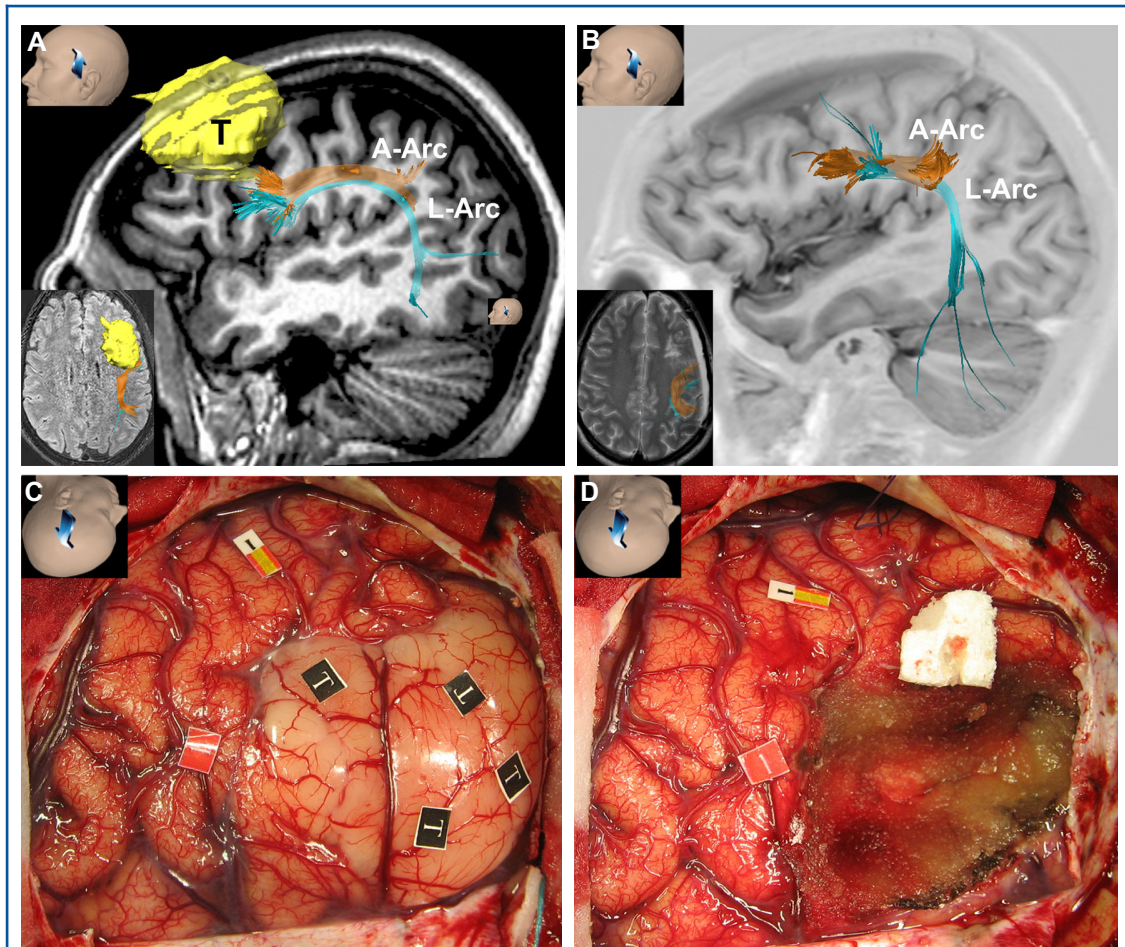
A 43-yr-old, trilingual (Spanish, English, and French), right-handed man with a left frontal glioblastoma. The patient had 2 partial seizures with dysphasia one week before admission. No preoperative neurological deficit was observed. A, Preoperative sagittal fluid-attenuated inversion-recovery (FLAIR) magnetic resonance images with diffusion tensor imaging tractography reconstruction of the tracts terminating at the ventral precentral fiber intersection area (VPFIA). The tumor is anterior to the VPFIA, in direct contact with the anterior termination of the anterior and long segments of the arcuate fasciculus. B, Postoperative sagittal FLAIR magnetic resonance images with diffusion tensor imaging tractography reconstruction of the tracts terminating at the VPFIA. The residual tumor volume was 4.2 mL. C, Intraoperative photograph taken before tumor resection in which the frontal, parietal, and temporal left lobes are exposed. Intraoperative electric stimulation of the cortex and white matter immediately posterior to the tumor elicited speech arrest. These areas were located with neuronavigation corresponding to the VPFIA. Intraoperative cortical electric stimulation elicited the following responses: Spanish flags 1, 2, 4, and 5 = speech arrest; Spanish flag 3 = dysarthria; Spanish flag 6 = anomia; English flags 1 and 2 = phonemic paraphasia; French flags 1 and 2 = phonemic paraphasia; Red tag 2 and 3 = lower lip movement. D, Intraoperative photograph taken after tumor resection. Resection was pursued until eloquent structures were encountered around the surgical cavity. Intraoperative electric stimulation of the white matter elicited the following responses: Spanish flag 8 = semantic paraphasia. The final pathology was glioblastoma.
